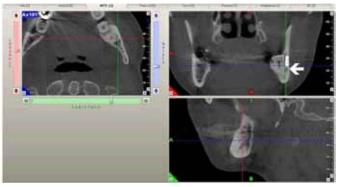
The cone beam computed tomography scan showing clearly the buccal position of the inferior alveolar canal (white arrow), the root anatomy in the coronal plane and their exact conformation. The extent and depth of buccal bone removal can be planned accurately (white bar).
